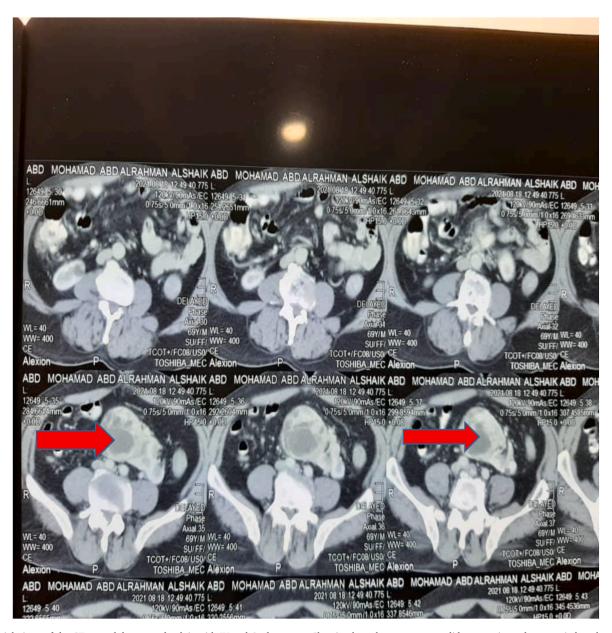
Axial views of the CT scan abdomen and pelvis with IV and Oral contrast. Showing huge heterogeneous solid retroperitoneal par aortic lymph nodes mass with Central necrosis.
